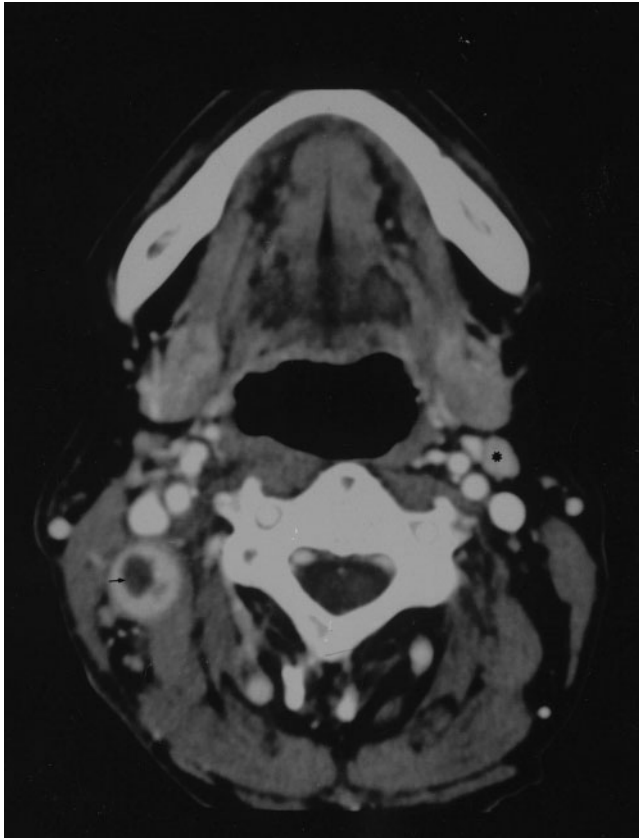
Axial contrast-enhanced CT scan showing a right sided enhancing lymph node with a central rounded non-enhancing area (small arrow). A homogeneously enhancing lymph node is also noted on the left side (*).
